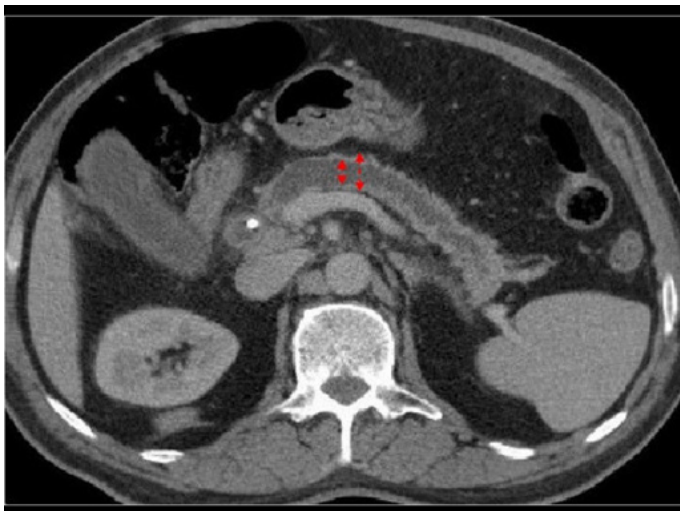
Axial contrast-enhanced computed tomography demonstrating the ratio of pancreatic duct caliber to width of gland (including duct).
